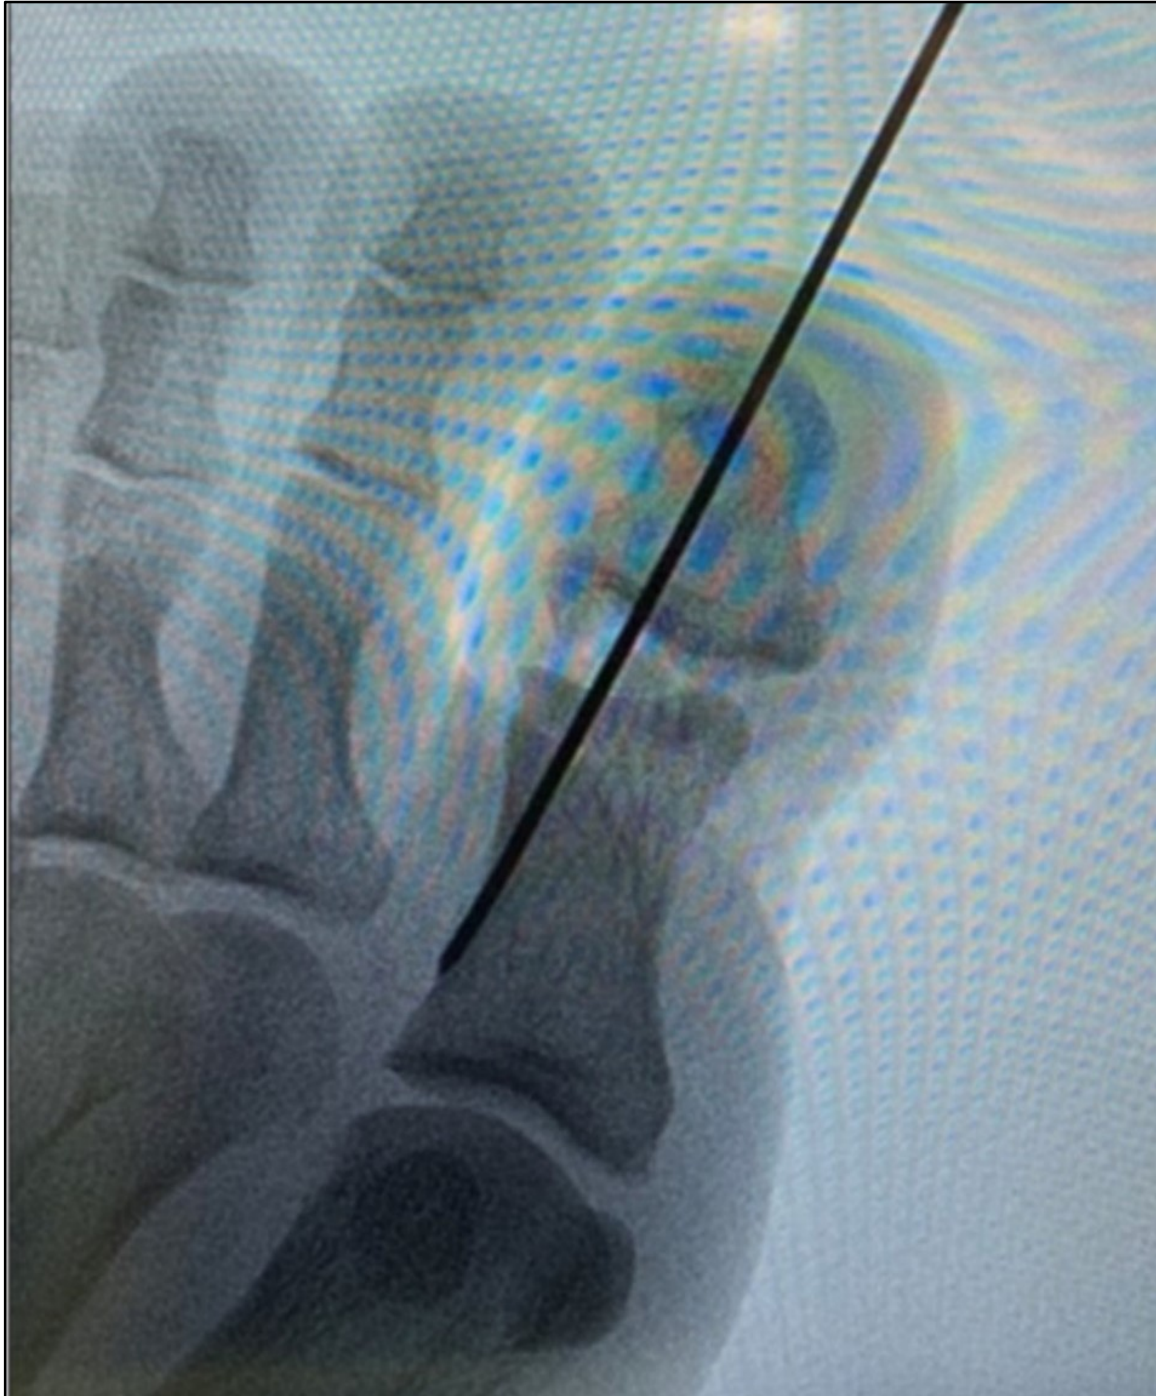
Intraoperative X-ray of the left great toe after removing the bony fragments. It shows a clear joint space, with K-wire in place percutaneously inserted to maintain the reduction.
